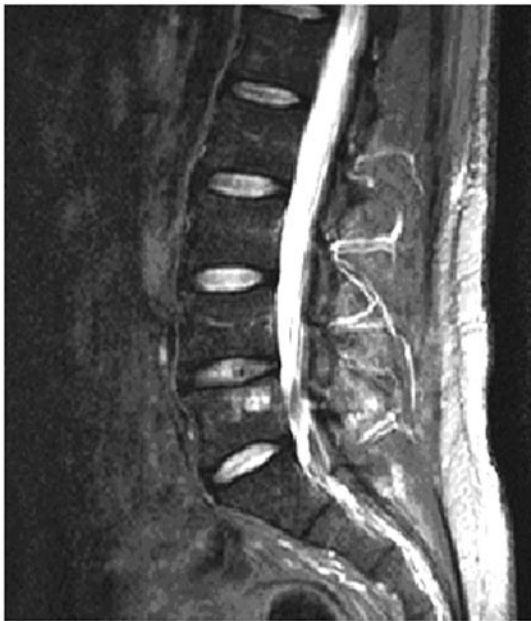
T2-weighted image of L5 hemangioma located at the posterior vertebral body near the superior end-plate.
